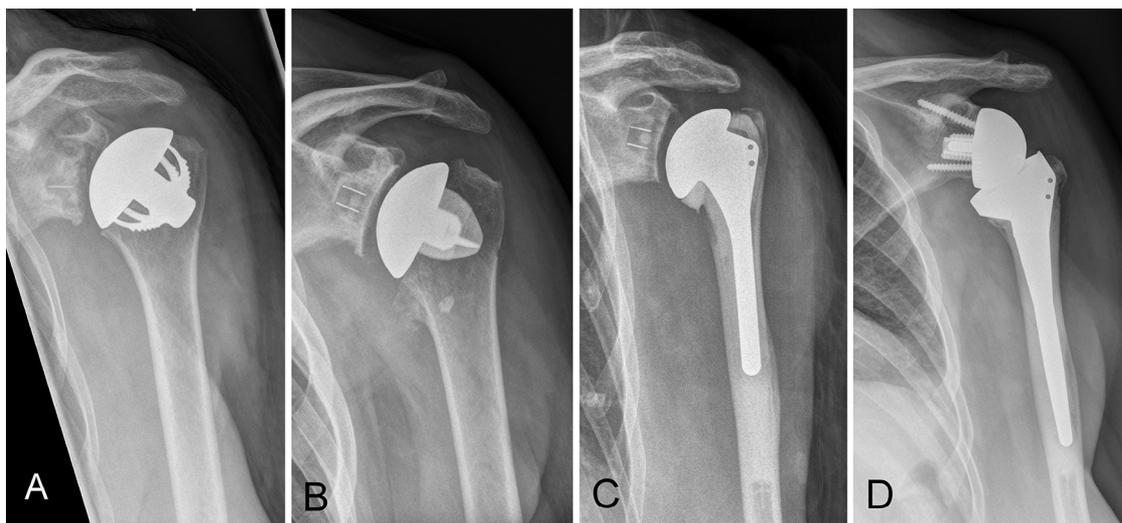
Anteroposterior radiographs of the shoulder of 4 different patients demonstrating the total shoulder prosthesis used in this study: (A) The Total Evolutive Shoulder System (TESS; Biomet, Inc., Warsaw, IN, USA), (B) the Simpliciti shoulder system (Tornier, Bloomington, MN, USA), (C) the Aequalis Anatomical Shoulder System (Tornier), and (D) the Aequalis Reversed Shoulder Prosthesis (Tornier).
